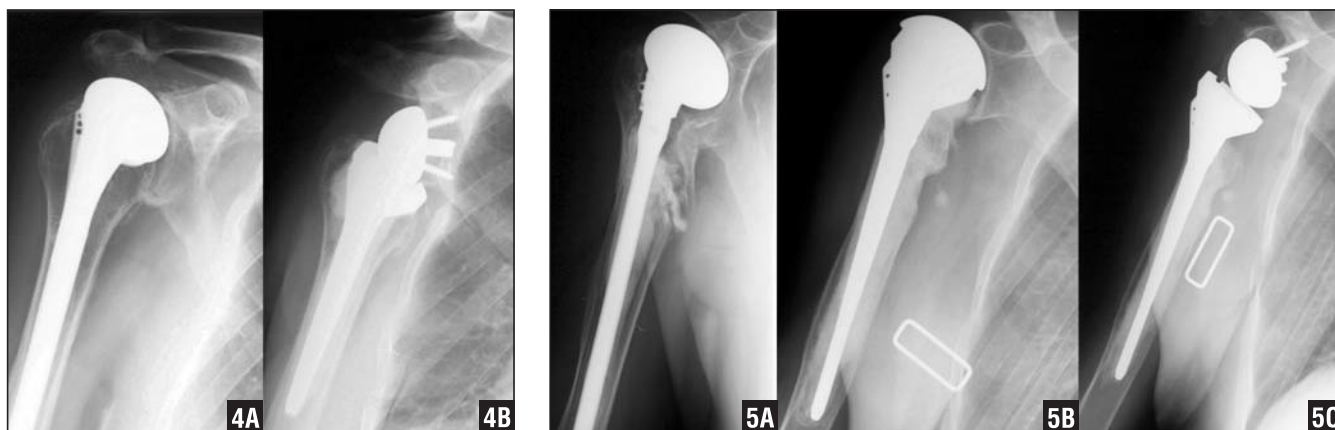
Cranioanterior dislocation (A). Postoperative radiograph (B). Figure 5: Periprosthetic infection with pseudarthrosis (A). Delta intermediary head (intermediate stage, not used in this series) (B). Conversion to an inverse prosthesis with implantation of a metaglene and exchange of the intermediary head for an epiphysis after elimination of infection (C).
